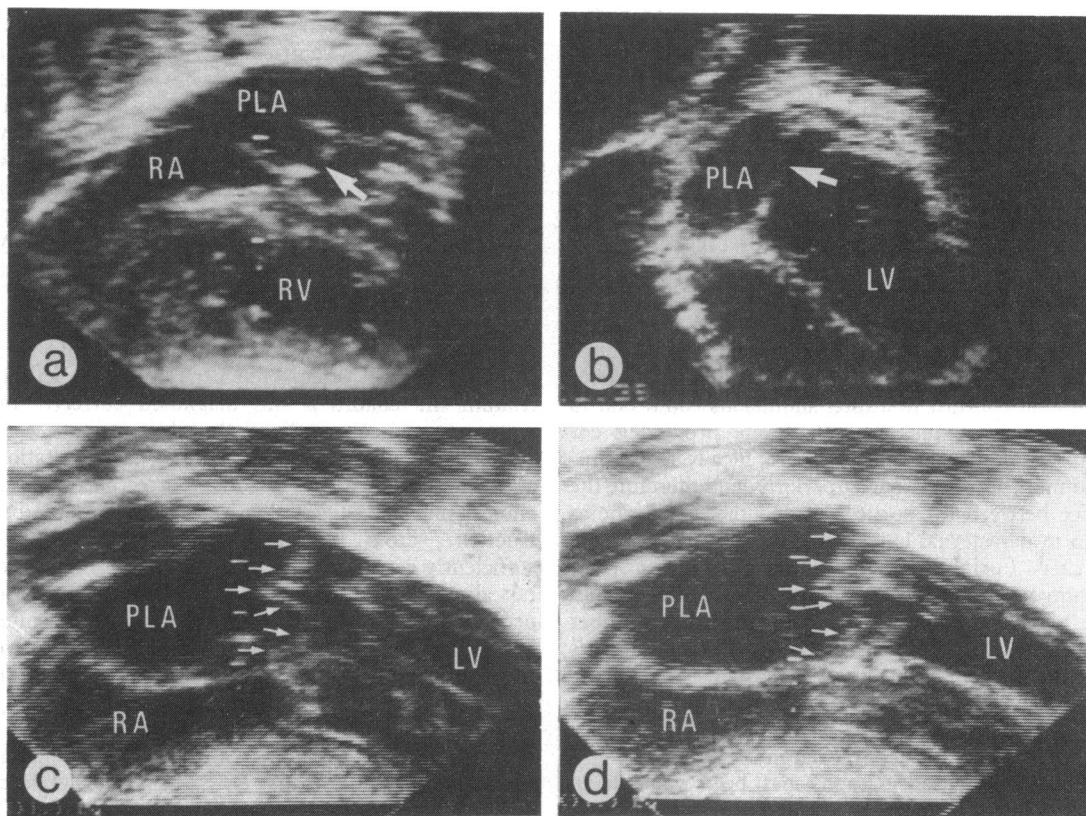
Cross sectional echocardiographic appearances in four chamber view. (a) Case 2: inferior echocardiographic plane in parasternal four chamber view shows (arrow) an apparent defect in the membrane. (b) Case 3: inferior plane of an apical four chamber view, shows (arrow) an apparent defect in the membrane. It is noteworthy that the proximal left atrium extends so far medially that it is to the right of the interventricular septum. (c) and (d) case 1 in the subcostal four chamber view show the membrane (small arrows) moving into the mitral valve funnel in diastole and again a distinct double arch appearance. The medial arch of the membrane shows two minor areas of dropout in the same position as the defect seen in case 2. PLA, proximal left atrium; RA, right atrium; RV, right ventricle; LV, left ventricle.
